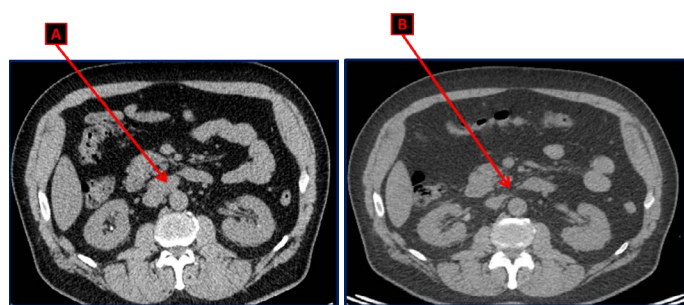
CT scan of the abdomen and pelvis showing the magma of retroperitoneal lymphadenopathies in the aortocaval space (A) upon recurrence. These lymph nodes disappeared after 4 cycles of chemotherapy with Cisplatin and Etoposide (B).
